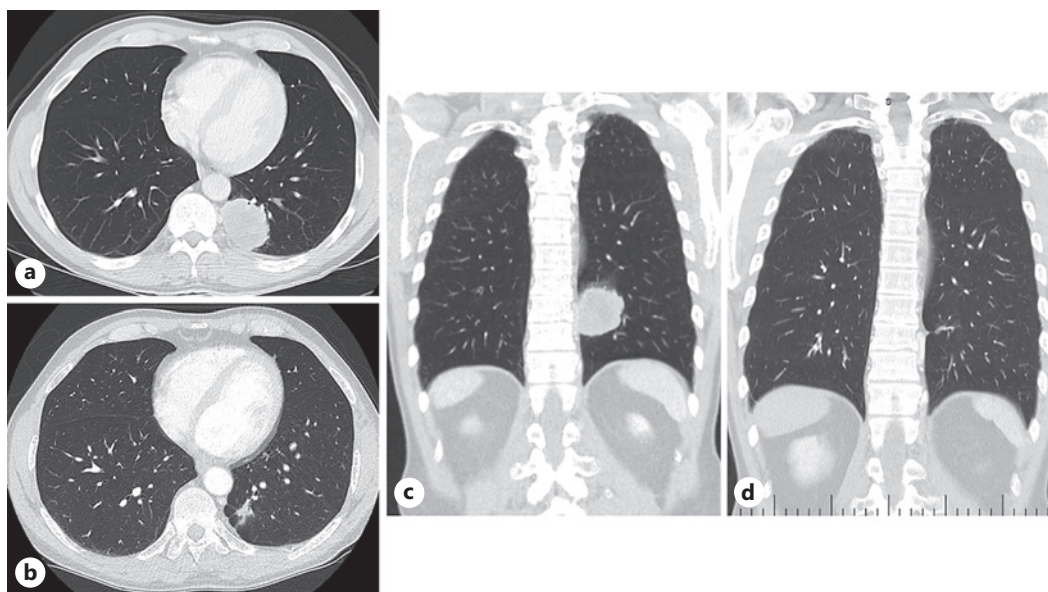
CT of the chest in axial (a, b) and coronal slices (c, d): prior to immunotherapy (a, c); and following 21 months of immunotherapy, demonstrating radiological response of the lung metastases and hilar lymphadenopathy to pembrolizumab (b, d). CT, computed tomography.
